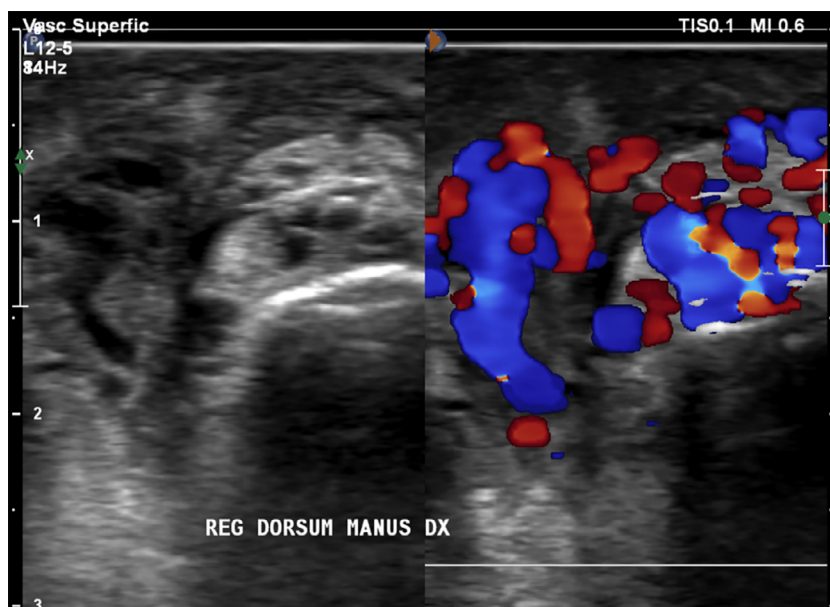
Initial Doppler ultrasound examination. Doppler ultrasound identifies the vascular nidus, with a “bag of worm” appearance, at the dorsal region of the right hand.
